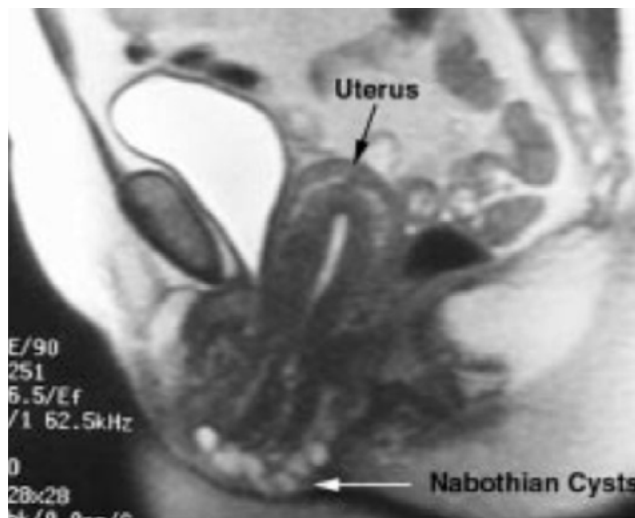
Pelvic Floor MRI: Uterine Prolapse.
